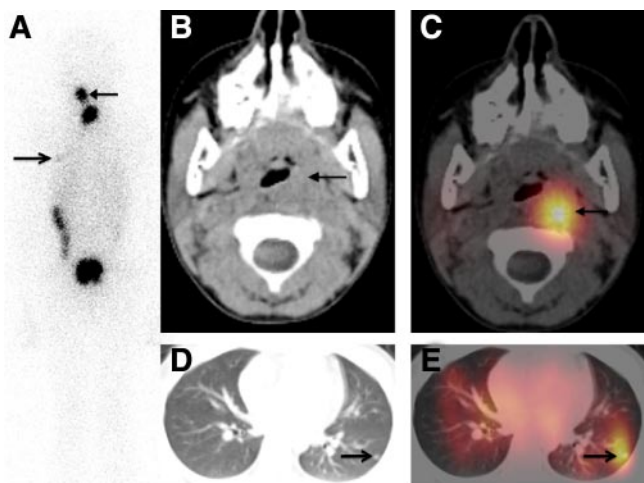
Postablation ¹³¹I WBS and SPECT-CT in patient 8 described in Table 2. A left paramedian neck focus scored as indeterminate on the posterior view of planar WBS (A) was ascribed to retropharyngeal lymph-node involvement and scored positive on SPECT-CT (B and C; CT and fused SPECT-CT transaxial slices). Also, a left thoracic focus of moderate intensity on WBS was clearly confirmed positive on SPECT-CT in front of a 5-mm lung nodule (D and E).
